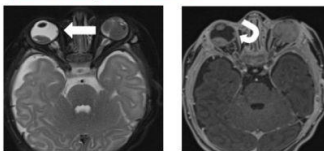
(left) Axial T2-weighted MRI image and (right) axial T1-weighted post-contrast image of a 2-month-old girl with retinoblastoma in both eyes. There is a T2 hypointense focus (arrow) on the medial aspect of right retina, which is suggestive of subretinal seeding.
